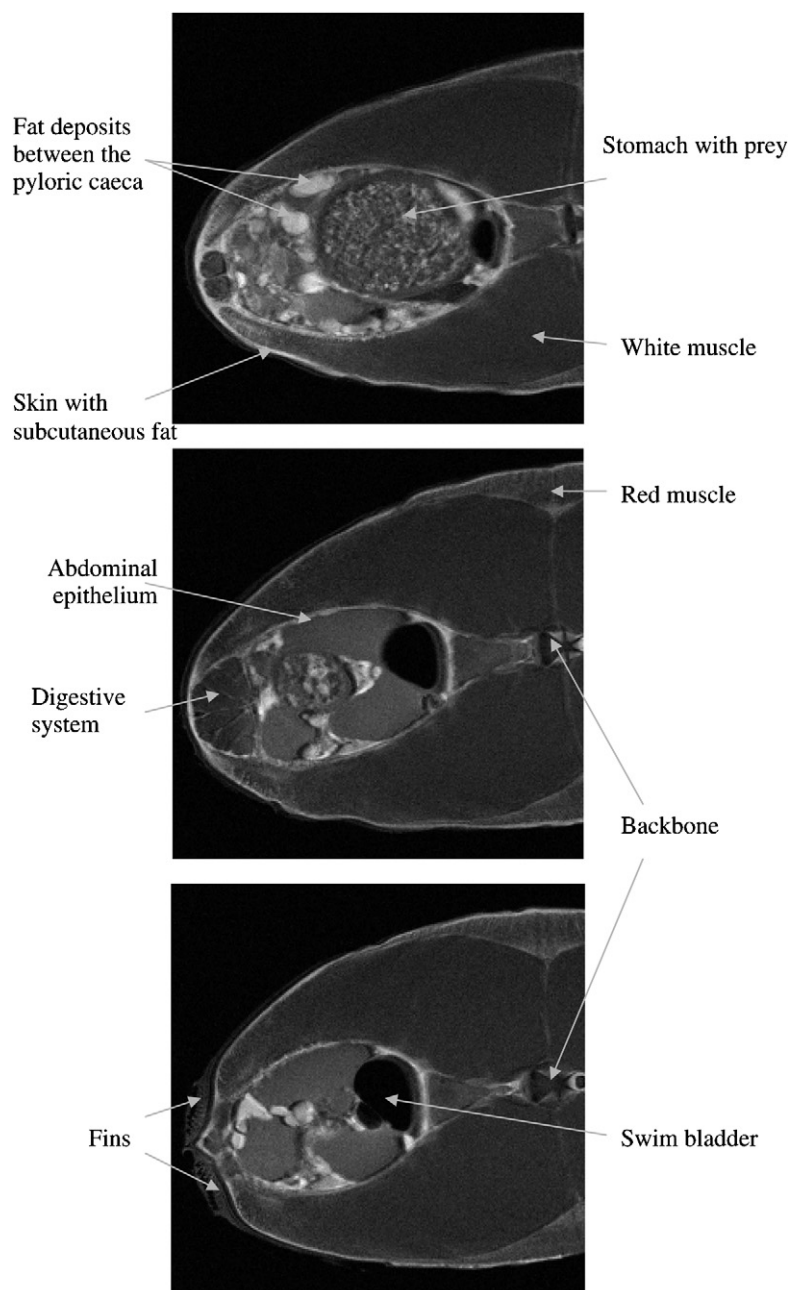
Three MRI slices of herring showing several anatomical structures.
